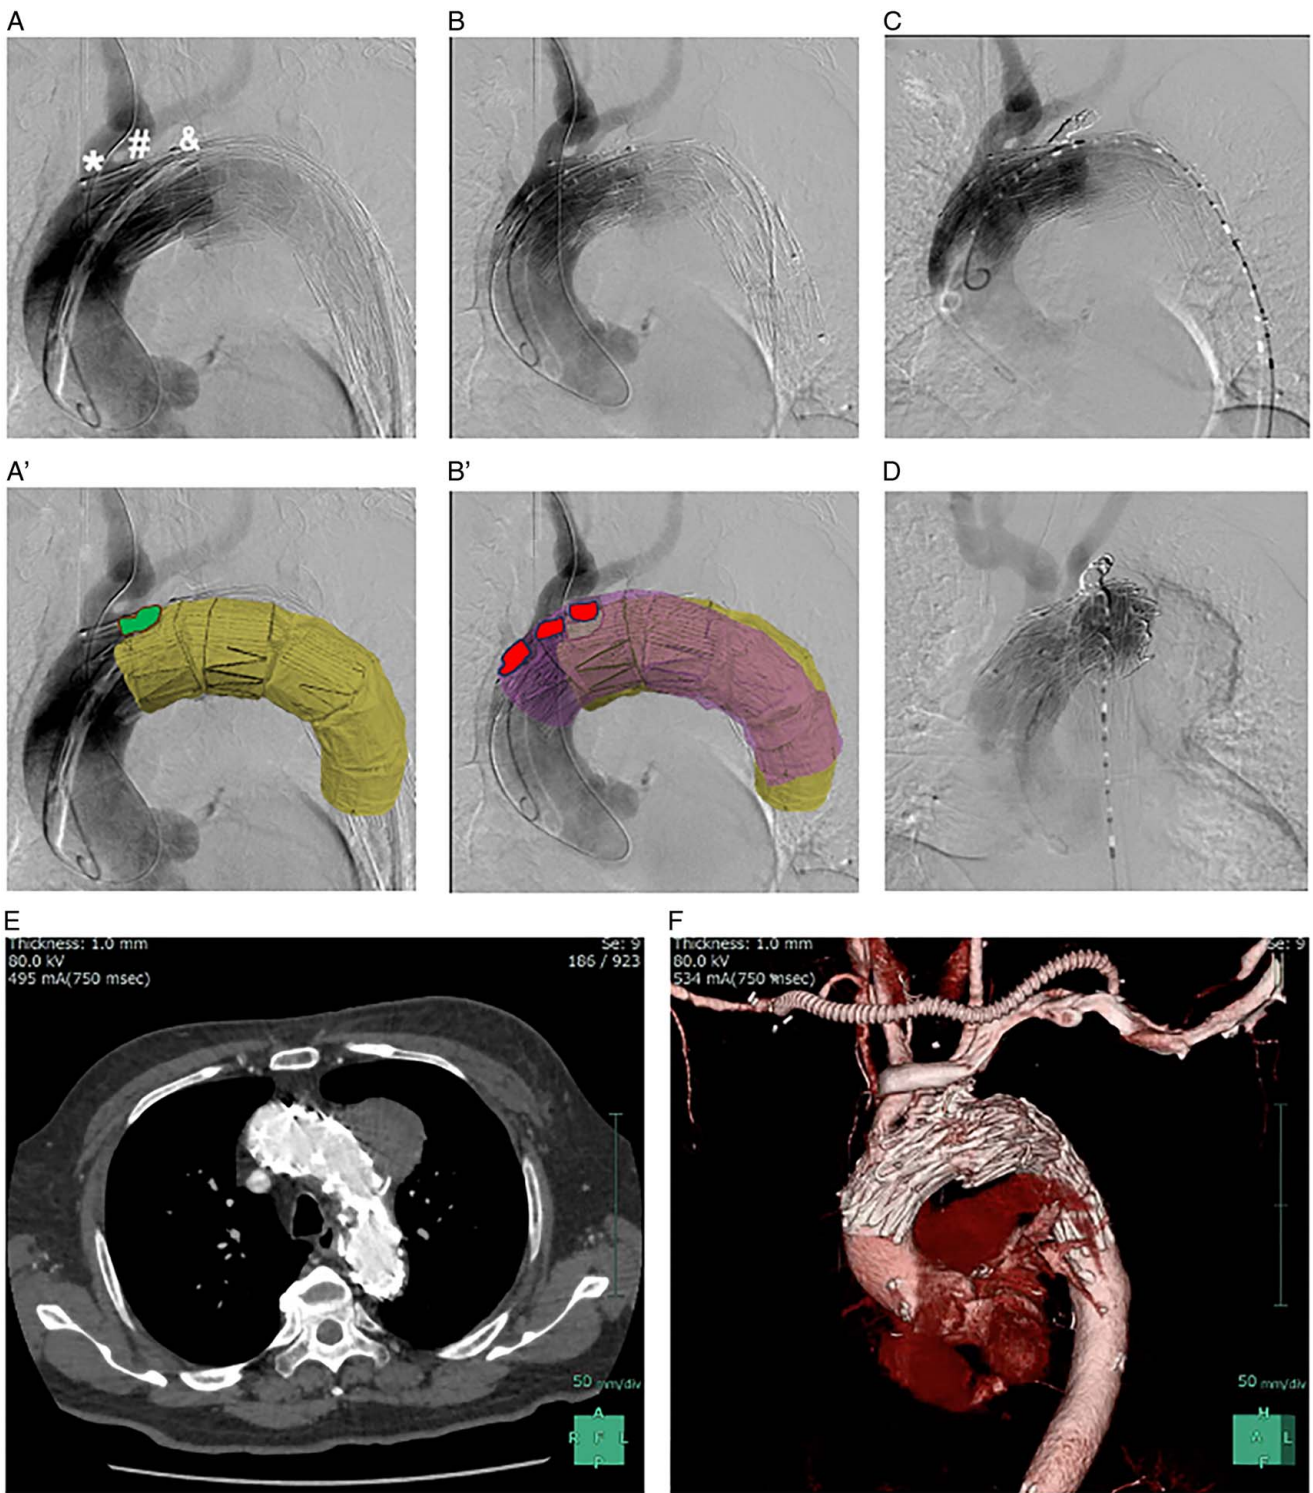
Perioperative images of angiography. (A) Angiography after implanting the distal-side stent-graft shows the patency of both the left cervical artery and the brachiocephalic trunk were maintained. (*: brachiocephalic trunk, #: Left cervical artery, &: Balloon for occlusion of left subclavian artery). (A') The distal-side stent-graft position was visualized using previous angiography image. The yellow portion indicates the body of one fenestrated-stentgraft, while the green segment indicate the locations of one fenestration aperture of this stentgraft. (B)Angiography after implanting the proximal-side stent-graft shows the patency of both the left cervical artery and the brachiocephalic trunk were maintained. (B') The proximal-side stent-graft position was also using angiography image. The purple portion indicates the body of the proximal-side stent-graft, while three red segments indicate the locations of three-fenestration apertures of this stentgraft. (C, D) Final angiographies after coiling the left subclavian artery showed that the patency of both the left cervical artery and the brachiocephalic trunk was ultimately maintained, and there were no endoleakages. (D) Postoperative enhanced computed tomography (CT) at 1 week after surgery. The axial view indicates the absence of endoleakages and the thrombosis of the cavity of the aortic aneurysm outside the stent-graft. (A) Postoperative three-dimensional CT images at 1 week after surgery.
